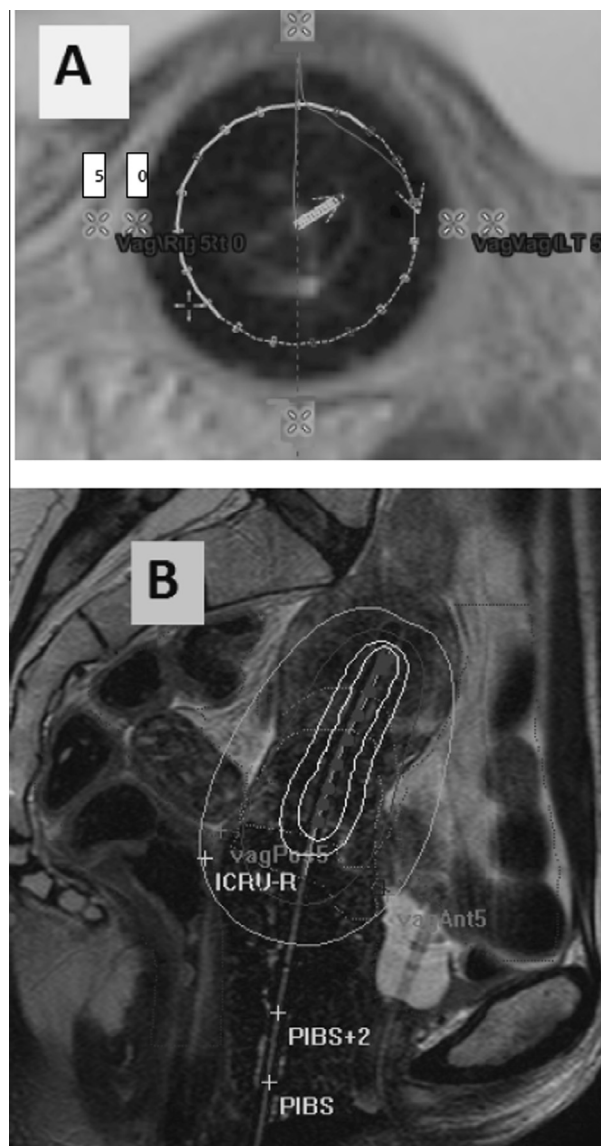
(A) A transverse MRI section at the level of ring applicator showing cross marks of the vaginal points. Lateral vaginal dose points were inserted at the surface of the vaginal applicator (0 mm) and at 5 mm depth; anterior and posterior vaginal points were placed at 5 mm depth. (B) a sagittal MRI section showing placement of ICRU recto vaginal point (ICRU-R), the posterior inferior border of the symphysis pubis (PIBS) and PIBS + 2 points along the tandem applicator.
